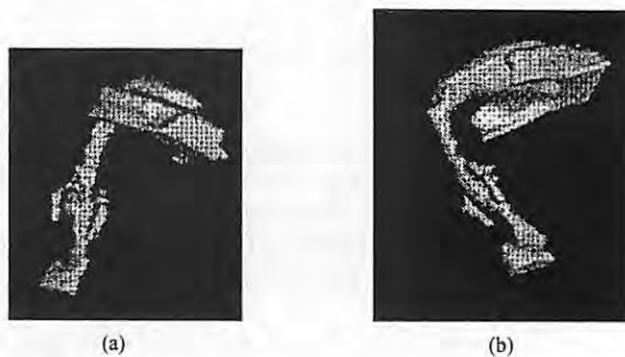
Shaded surface display (using MRI) of the vowel /a/ including the teeth: a) left tilted frontal view - flat surface in the upper right portion of the picture is the mouth termination plane, b) left tilted, inferior view - the "fins" that are visible on the left and right sides of the oral region are due to the included presence of the teeth.
